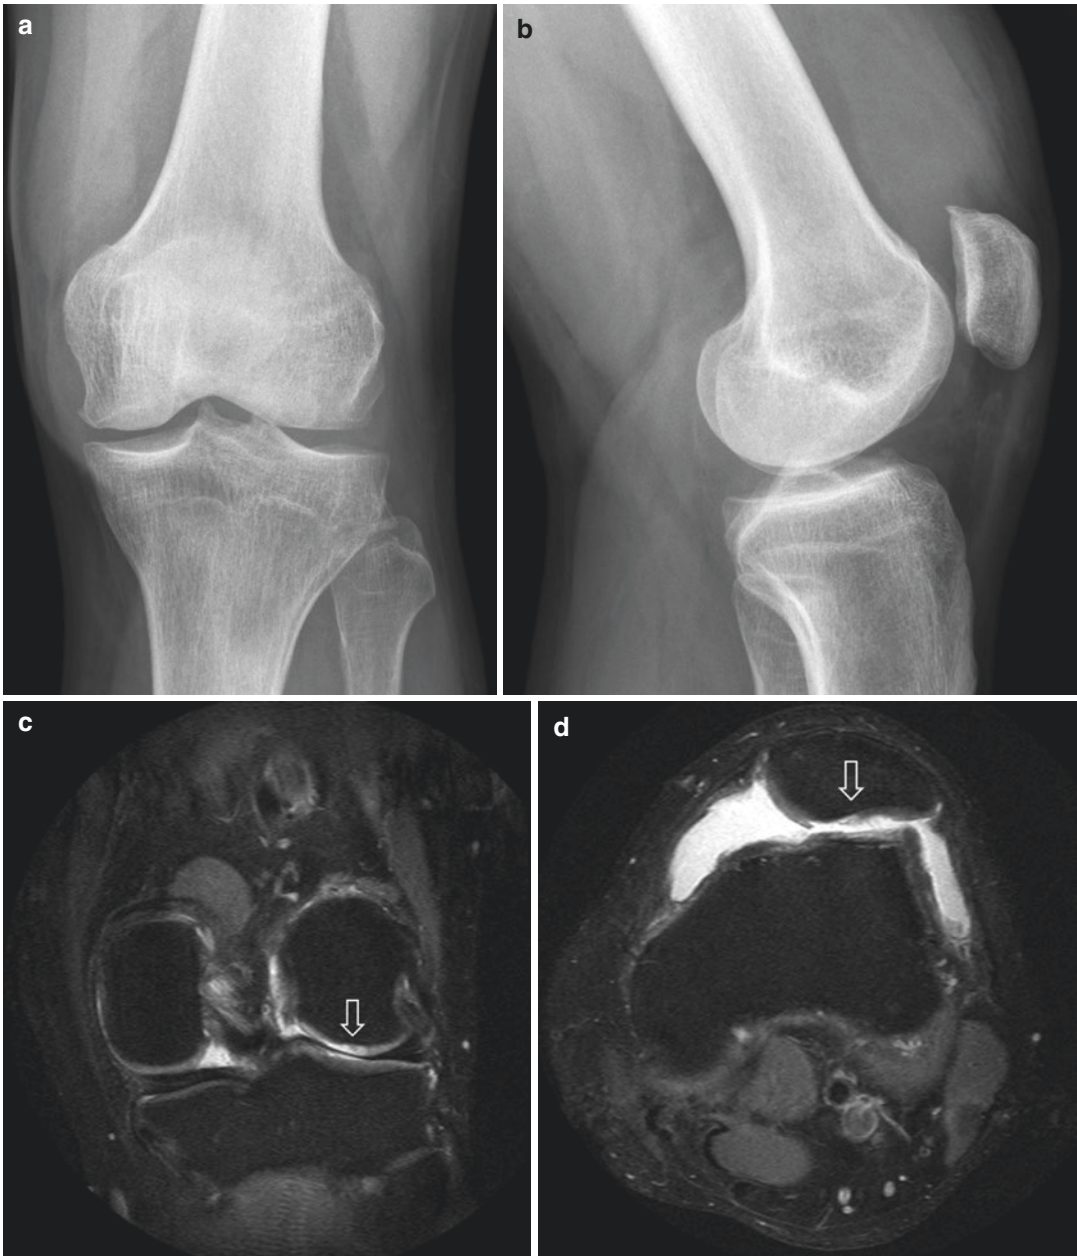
A 44-year-old man who presented with chronic left knee pain. (a) Frontal and (b) lateral radiographs of the left knee show mild osteoarthritis with small marginal osteophytes and relative preservation of the joint spaces. A joint effusion is also noted. (c) Coronal and (d) axial fat-suppressed PD-W MR images of the left knee show
